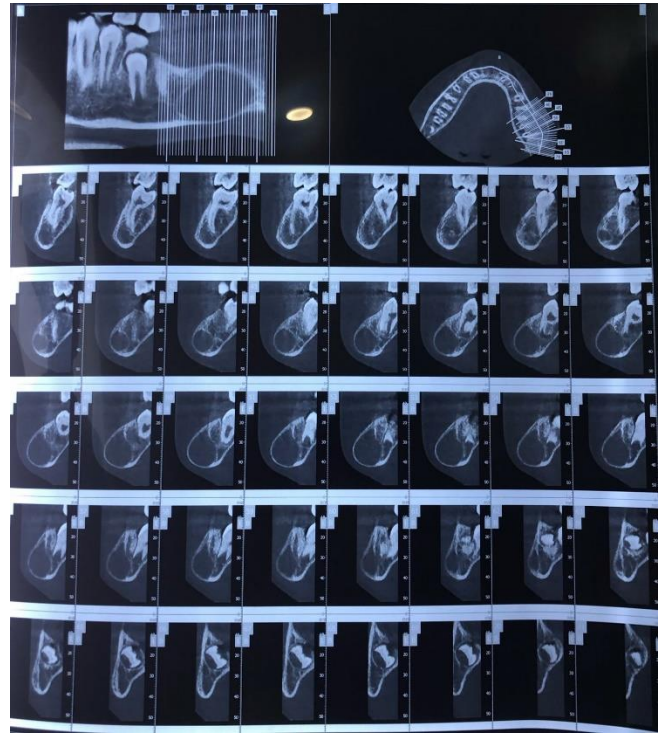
CBCT showing the well-defined radiolucent lesion with thinning of the buccal cortical bone
